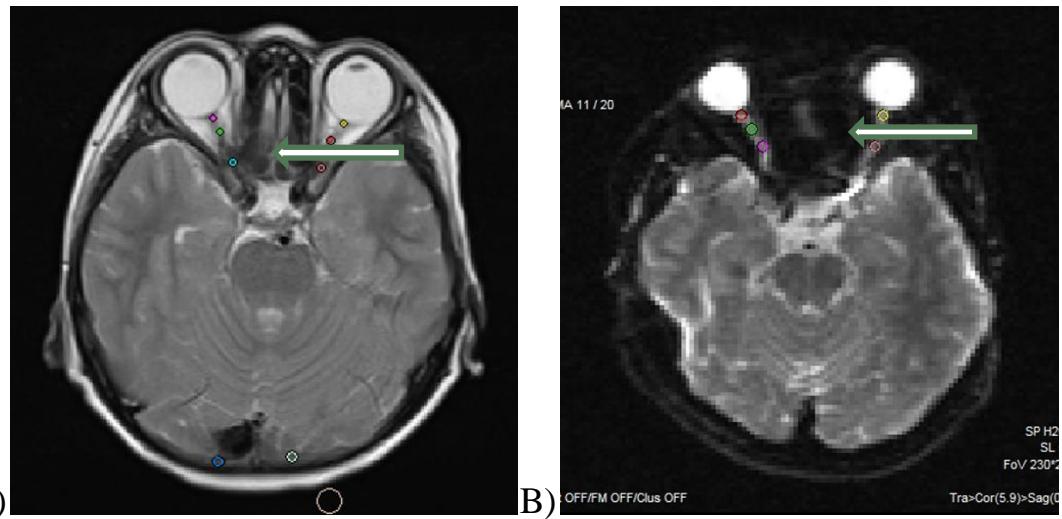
A) MRI of the brain. Selection of the region of interest in the projection of the optic nerve. B) FA map. Selection of the region of interest in the projection of the optic nerve on the fractional anisotropy map. FA is a value characterizing the integrity of the myelin sheath. MDC evaluates diffusion processes occurring in the longitudinal direction of the axon. Colored images were obtained in DEC (directional encoded color) maps (Fig. 2.3). In order to exclude as much as possible the receipt of false-positive results, color and black-and-white FA and DEC maps were used (Fig. 2.3).
